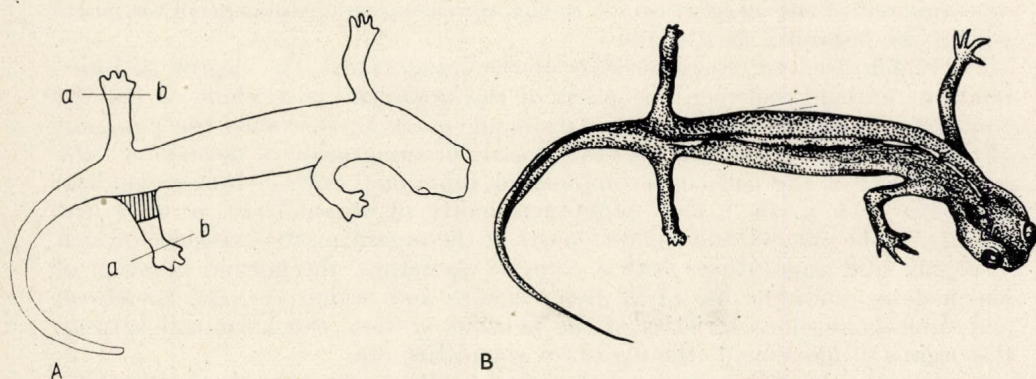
Regeneration of extremity of *Hynobius keyserlingii*. A — scheme of operation; B — the newt with regenerating extremities; the part of the right extremity (lined) has been treated with X-rays. a—b — the level of amputation having left a disk of tissues without X-ray treatment (after Zdruikovskaia)
